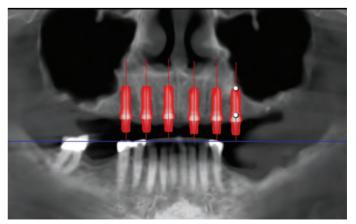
Radiograph demonstrating proposed surgical plan placement of Z-systems Z5M Dental implants
